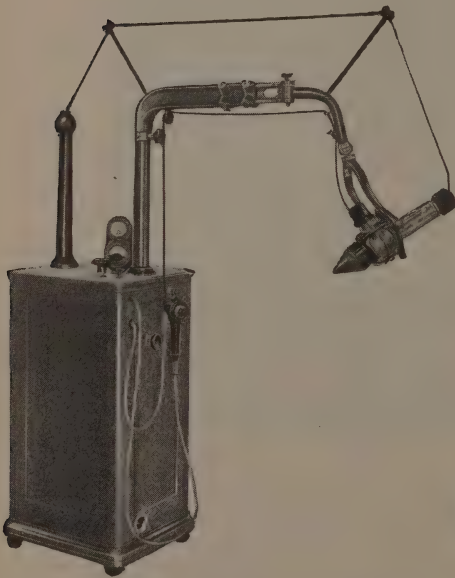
The Ritter Dental X-ray Unit.
